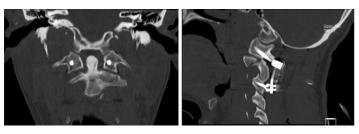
(Left) Coronal and (Right) sagittal computed tomography scan revealed the postoperative construct with C1-C3 fixation and restoration of alignment
